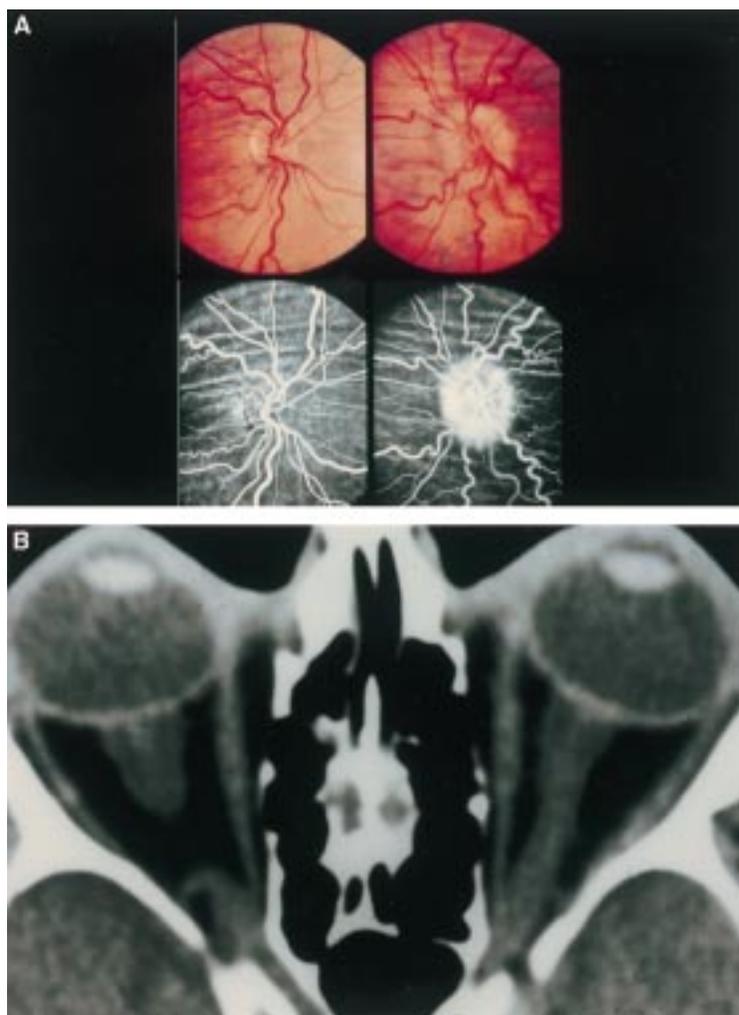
(A) Bilateral choroidal folds and unilateral papilloedema. Colour and fluorescein photographs demonstrating bilateral coarse choroidal folds and unilateral papilloedema in a patient (patient no 32, Table 3) with benign intracranial hypertension. (B) Distended nerve sheath and compressed globes. Computed tomograph scan of the same patient demonstrating dilated optic nerve sheaths. This patient presented with acquired hypermetropia. Examination revealed bilateral choroidal folds and a swollen left disc. The arrow denotes perineural cerebrospinal fluid.
